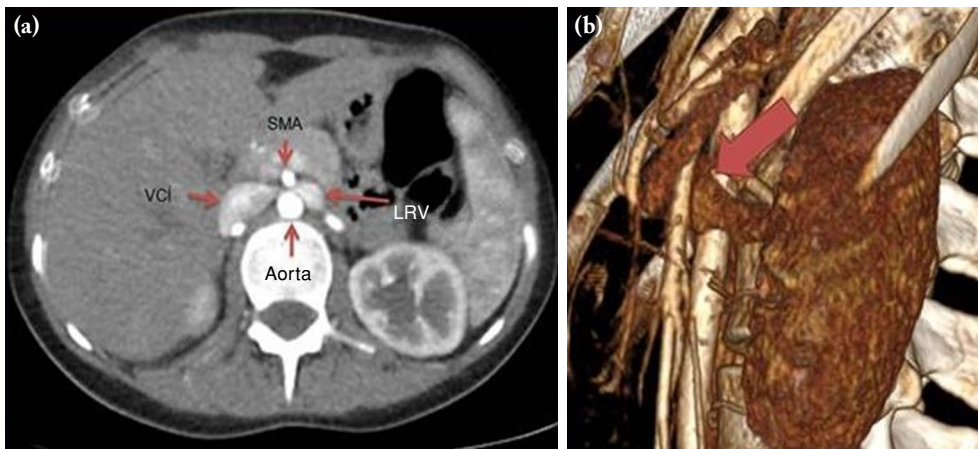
A computed tomography angiography showing the left renal vein compression at (a) transverse plane and (b) three-dimensional plane. SMA: Superior mesenteric artery; VCI: Vena cava inferior; LRV: Left renal vein; Ao: Aorta.
